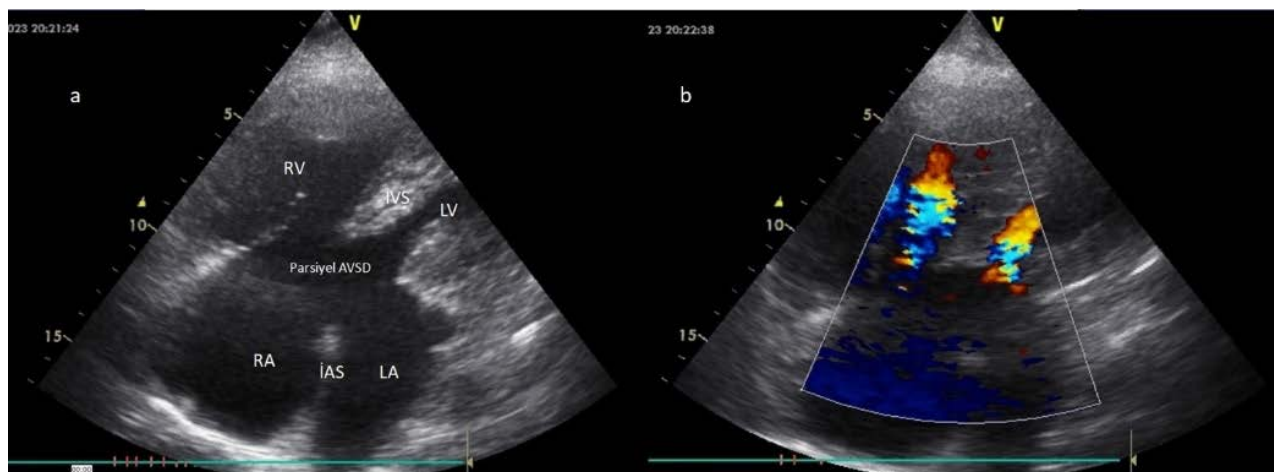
Partial atrio-ventricular septal defect (AVSD) appearance on echocardiogram.
